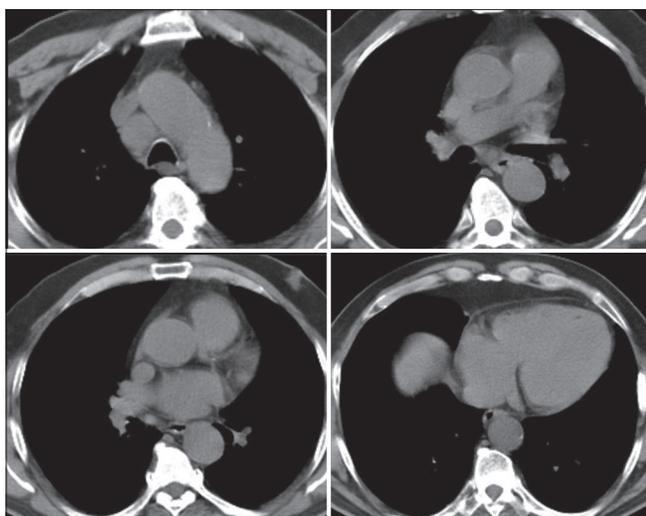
Mediastinal section of the case in thoracic computed tomography, lymphadenopathy in 4R
